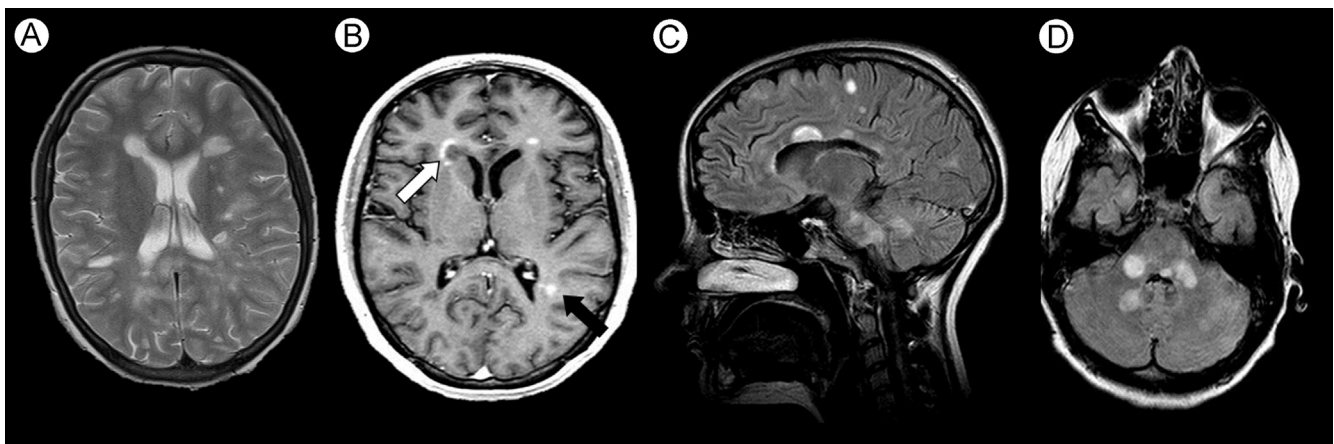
MS lesions. Typical periventricular (A) distribution of MS lesions on a T2-weighted image. Corresponding contrast-enhanced T1 image (B) shows solid enhancement (black arrow) and typical “open-ring” enhancement (white arrow). Sagittal (C) and axial (D) FLAIR with typical lesion distribution in the body of the corpus callosum and the cerebellar peduncle.
